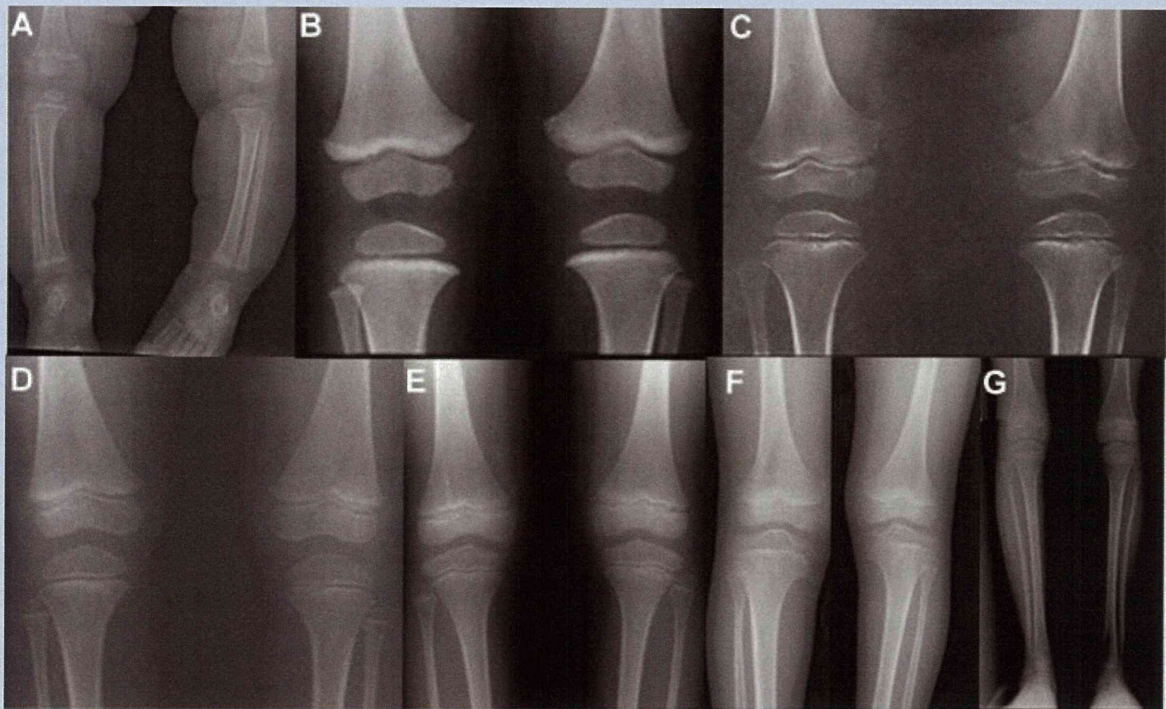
Radiographs of lower limbs. A: Patient 1 at age 6 months, (B) Patient 2 at age 1 ^{4/12} years, (C) Patient 3 at age 4 years, (D) Patient 6 at age 8 years, (E) Patient 7 at age 10 years, (F) Patient 4 at 10 years, (G) Patient 5 at 12 years. Metaphyseal changes are absent or very mild in the knee but the knee epiphyses are slightly flattened, notably in (B) and (C).
